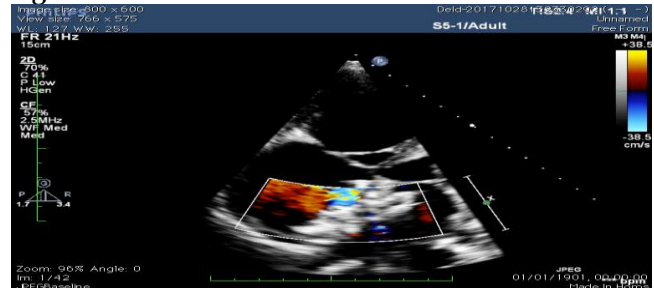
Echocardiogram showing right to left shunt through stent.
